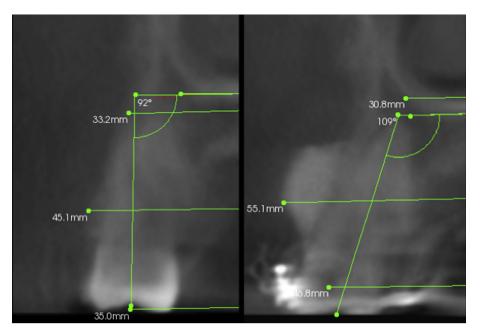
Preoperative and postoperative CBCT images demonstrating significant increase in the thickness of buccal plate despite a concomitant maxillary expansion procedure and orthodontic repositioning of teeth labially/buccally.
